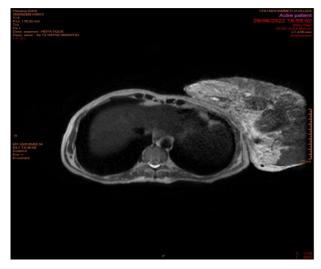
MRI T2 sequence
